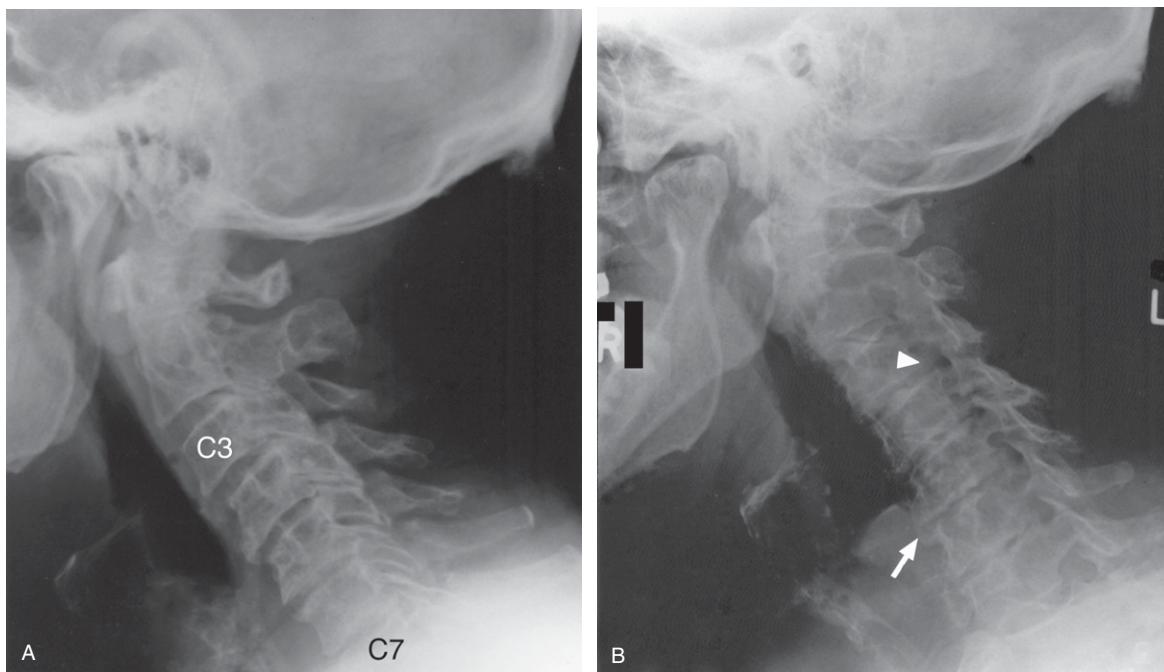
(A) Cervical spine lateral plain X-ray image showing the widespread osteoarthrotic degenerative changes involving the intervertebral and zygapophysial joints with disc space narrowing at C4–5, C5–6 and C6–7. Left (B) and right.
